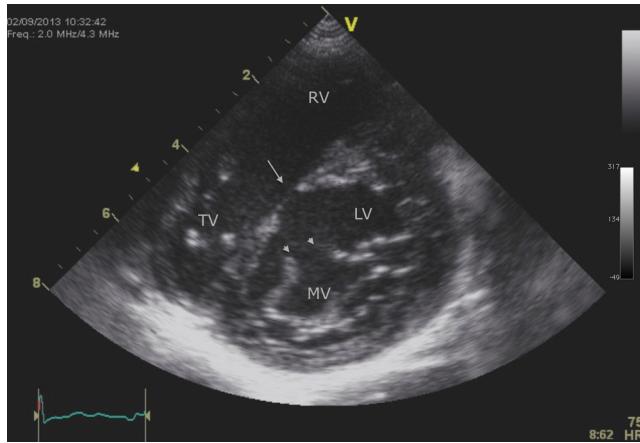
Case #4. TTE: short-axis parasternal view – mitral valve (anterior leaflet) cleft (short arrow) and VSD (long arrow).
